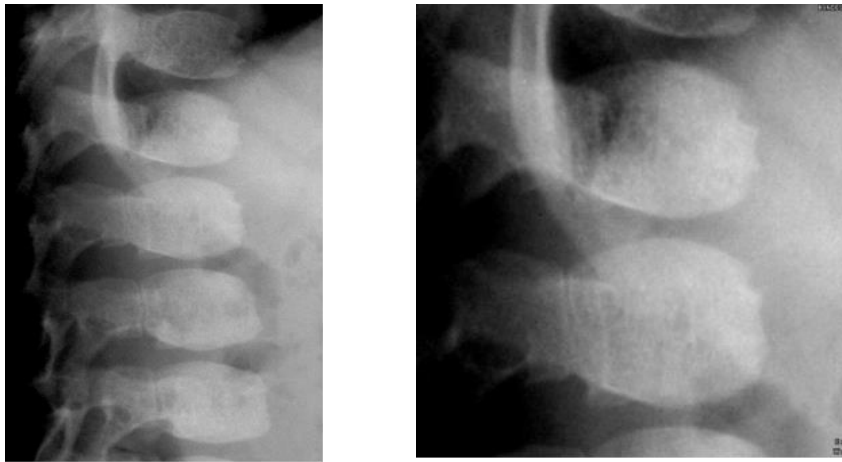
Lateral x-ray of the lumbar spine showing slight hypoplasia of the body of T12 and L1 with their slight dislocation dorsal and breaking of their anterior margins.
